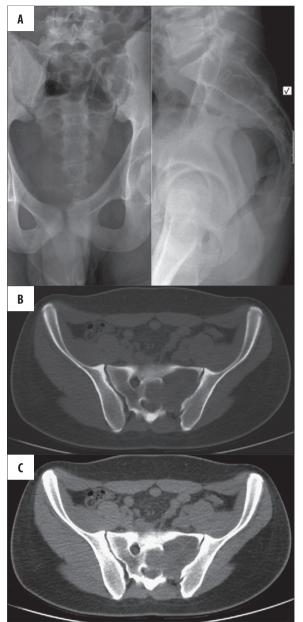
Patient Z.A. (A) Plain film. Osteolytic focus in the left lateral mass of the sacrum, difficult to assess due to gas in the bowels. (B,C) CT. ABC: mass in the sacrum on the left, without the signs of malignancy, with only a few fluid levels (B – bone window, C – soft tissue window).
